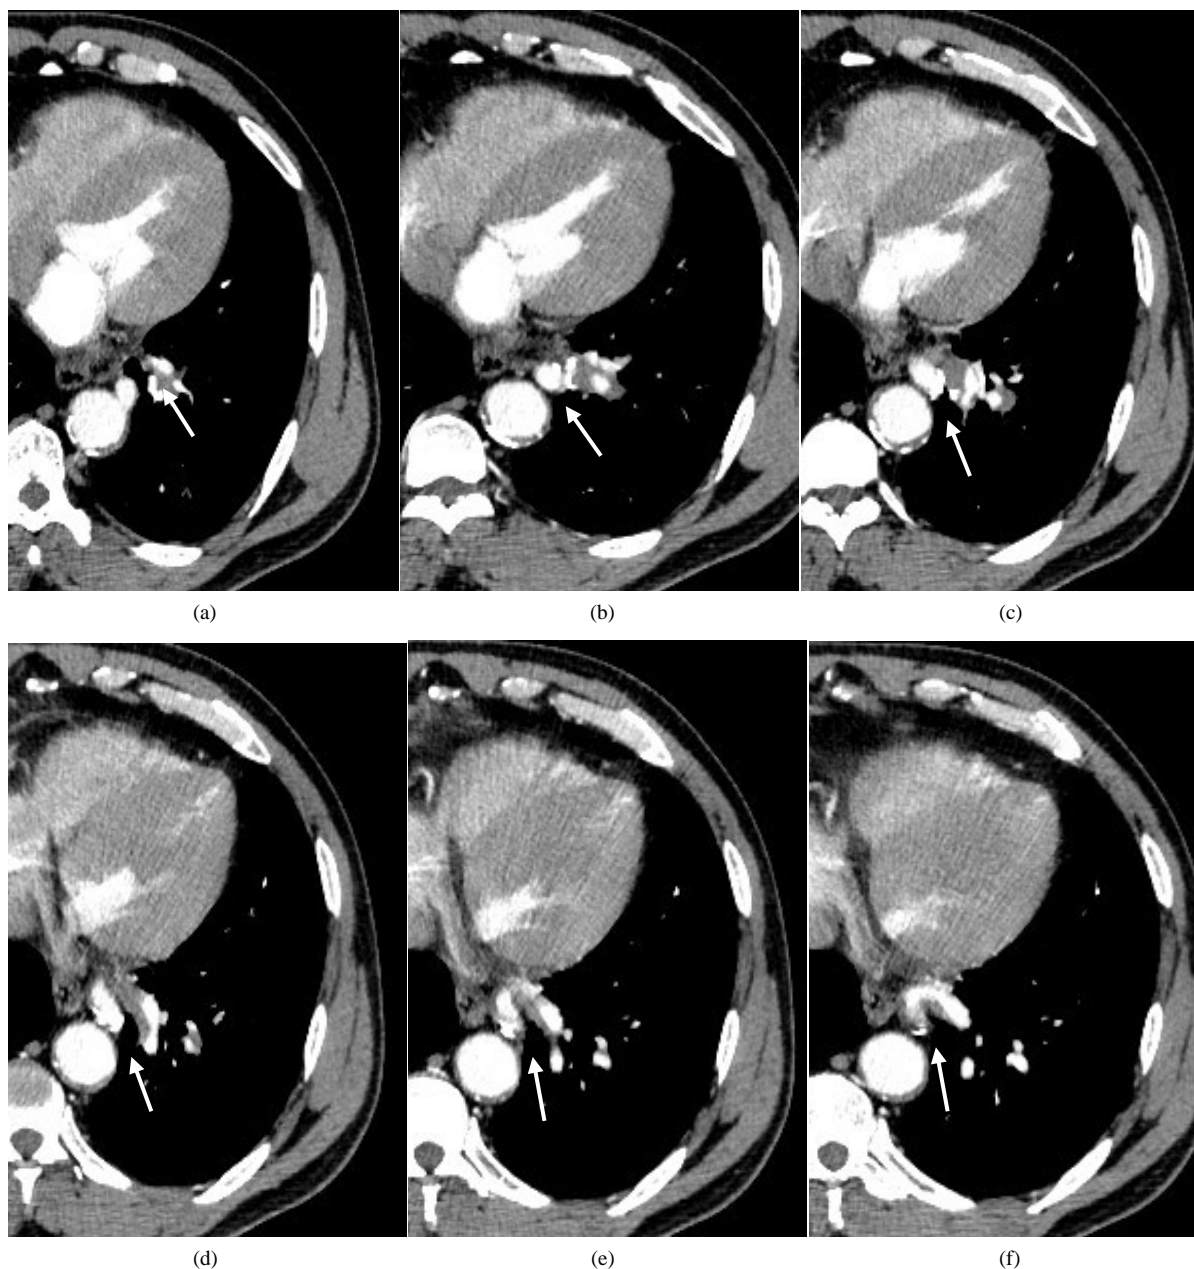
Chest CT shows a thickened thoracic aortic branch supplying the basal segment of the left lower lobe
